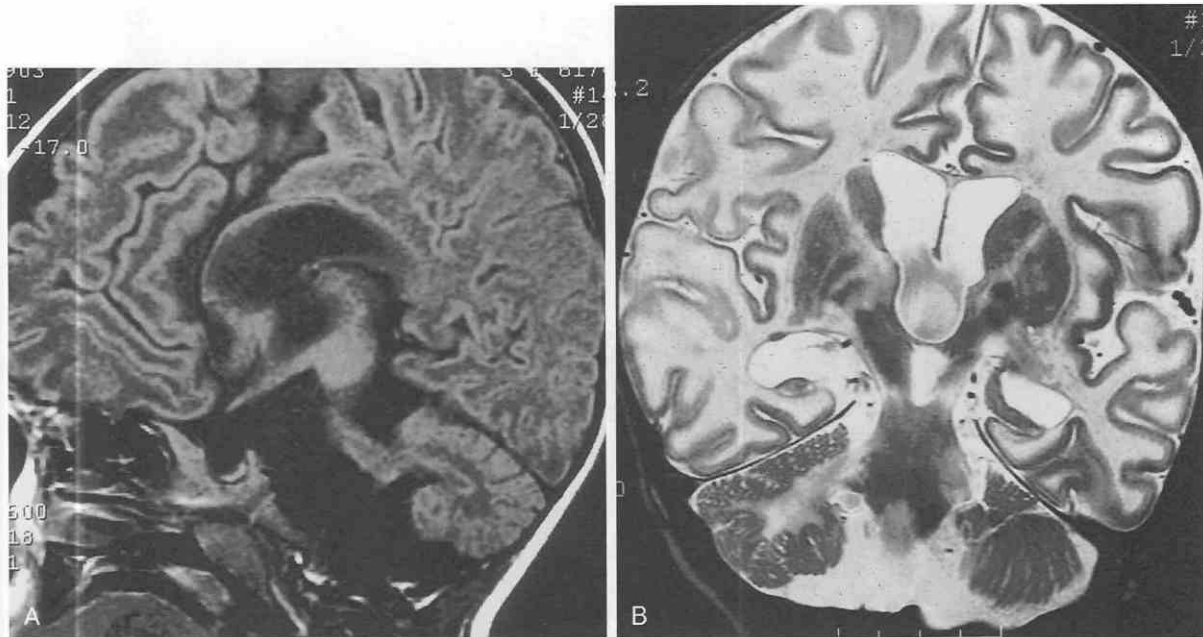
Tay-Sachs disease (hexosaminidase deficiency) in a 3-year-old girl with megalencephaly. A, T1-weighted sagittal MR image shows generalized white matter hypoattenuation and extreme hypogenesis of the corpus callosum (a nonspecific finding). B, T2-weighted axial MR shows extreme demyelination of virtually all white matter as well as characteristic T2 prolongation in thalami and lenticular nuclei.
